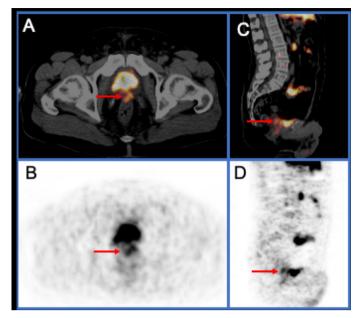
61-year-old patient, previous radical prostatectomy, Gleason grade 3, PSA before PET 0.19ng/ml. Axial ¹⁸F-1007-PSMA fused (A) and PET (B) images demonstrating prostatic recurrence (arrow). Sagittal ¹⁸F-1007-PSMA fused (C) and PET (D) images demonstrating prostatic recurrence (arrow).
